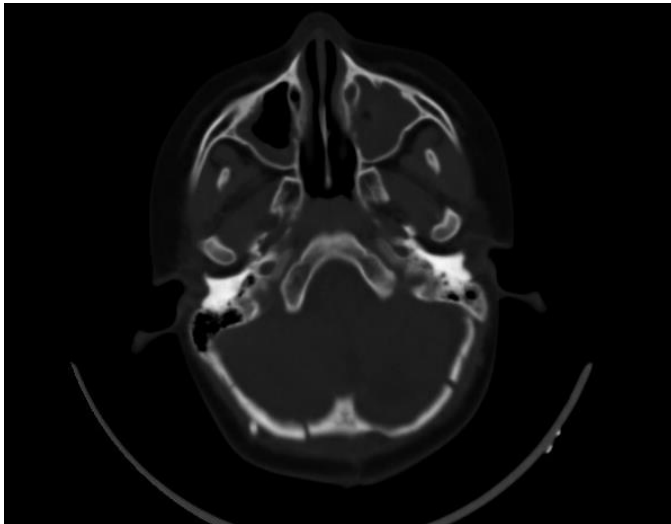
Post CT scan image.
